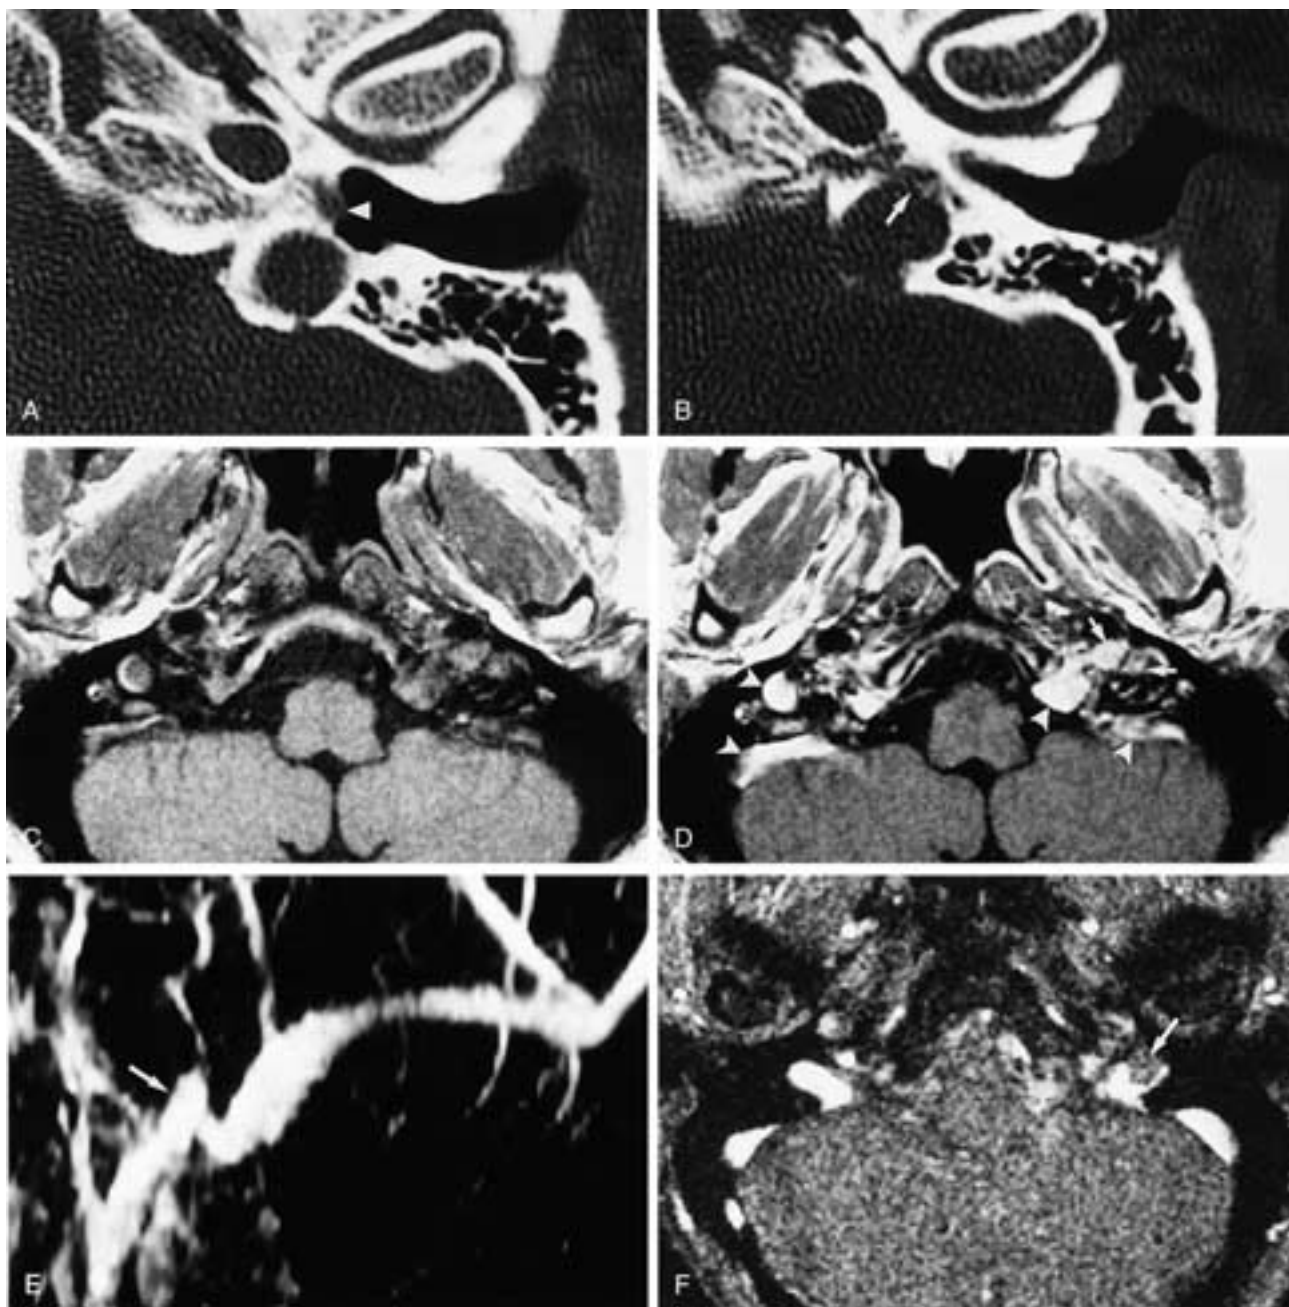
Small right jugulotympanic paraganglioma (glomus jugulare) requiring CT, MR imaging, and MRV for full delineation. A, CT shows a small otoscopically visible intratympanic pulsatile mass apparently confined to the tympanic cavity (*arrowhead*). B, CT, 2 mm below A, shows subtle tumor extension down the caroticojugular spine to the anterior wall of the inferior portion of the jugular fossa (*arrow*). C, Gadolinium T1-weighted image. C and D show multiple sites of enhancement. It is difficult to differentiate between slow flow enhancement (*arrowheads*) and true tumor (*arrows*). E, MRV (2D TOF, maximum-intensity projection) shows questionable indentation of the jugular bulb (*arrow*). F, MRV (2D TOF, individual partition) shows unequivocal tumor invasion (*arrow*) of the jugular bulb that is not apparent on A through E. The presence or absence of jugular bulb invasion is critical for selection of the surgical approach to the jugulotympanic paraganglioma.
